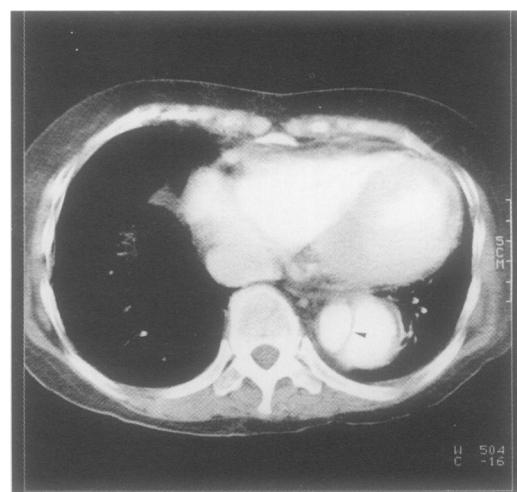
Axial contrast enhanced CT scan of distal thoracic aorta at level of the left ventricle. Presence of an intimal flap (arrowhead) across the aortic lumen at this section would have suggested aortic dissection. This was, however, found to be the undermined edge of a saccular aneurysm. The smaller compartment proved to be the true aortic lumen and the larger one to be the lumen of the saccular aneurysm at necropsy.
